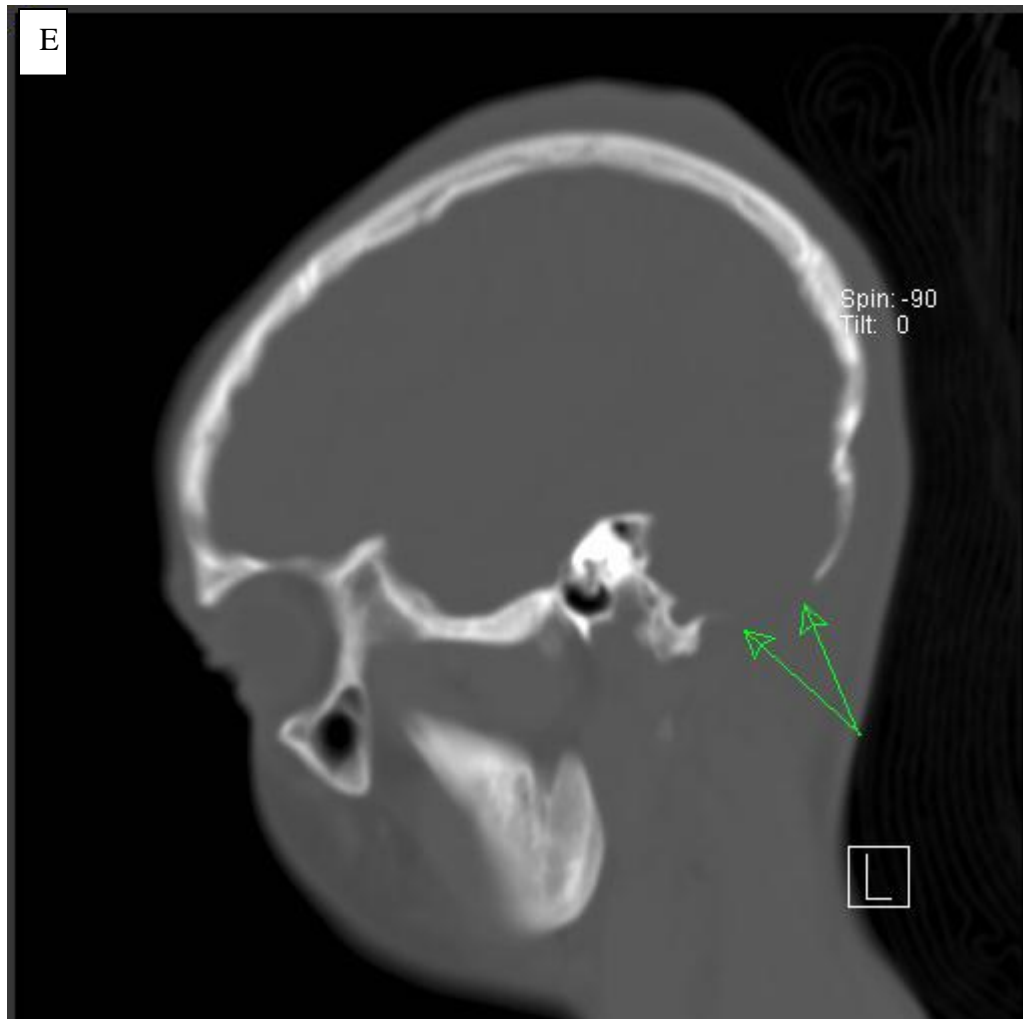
Computerized tomography (CT) scan (sagittal view) showing post-craniotomy of the left occipital bone (NF1 Individual Code 002).
